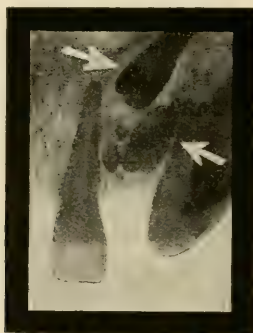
The upper arrow points to the permanent lateral incisor. The lower arrow points to an odontoma. (Radiograph by Flint, of Pittsburgh.)
